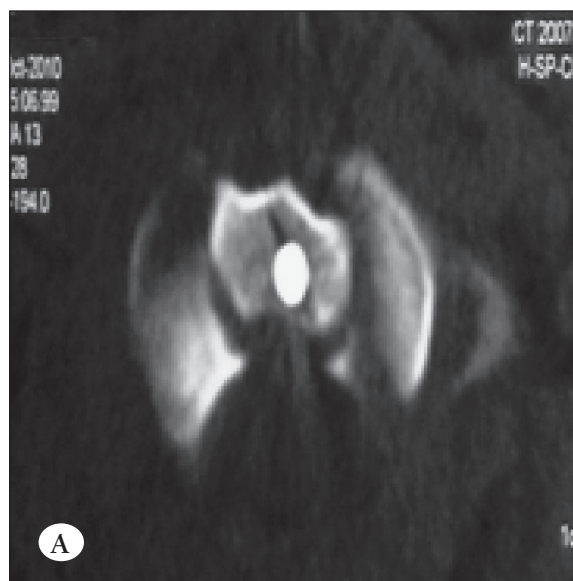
Axial section of cervical CT showing broken odontoid screw at the front part of the C2 body (3A). Sagittal section of cervical CT showing broken odontoid screw at the front part of the C2 body (3B).
